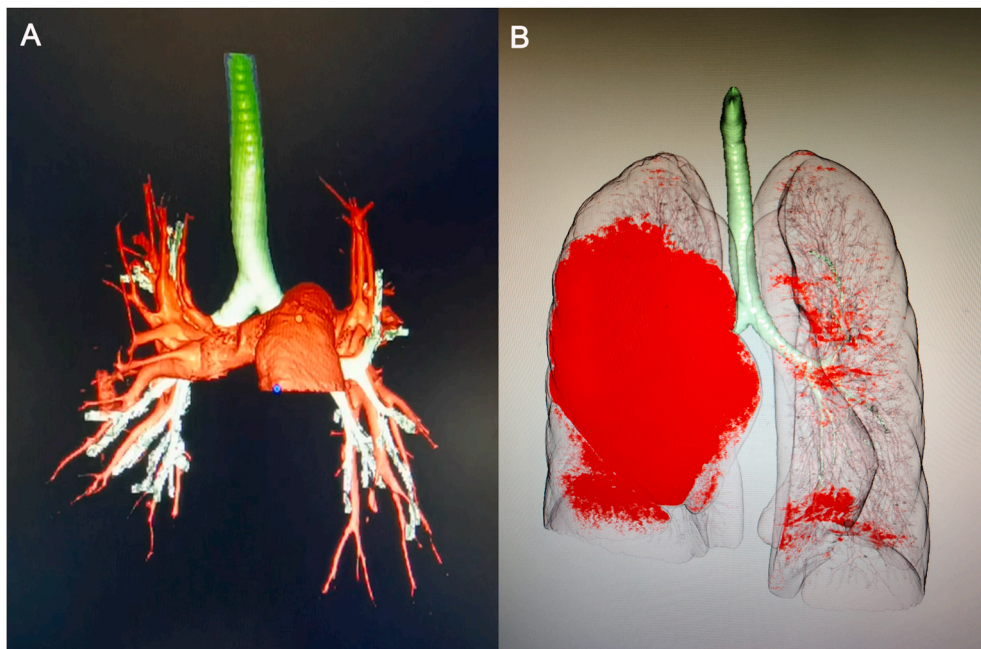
3D reconstruction CT showing (A) atresia of the B3 bronchial trunk of the right upper lobe (RUL) without communication with the right bronchial tree, and (B) the ratio (40 %) of RUL emphysema to right whole lung.
